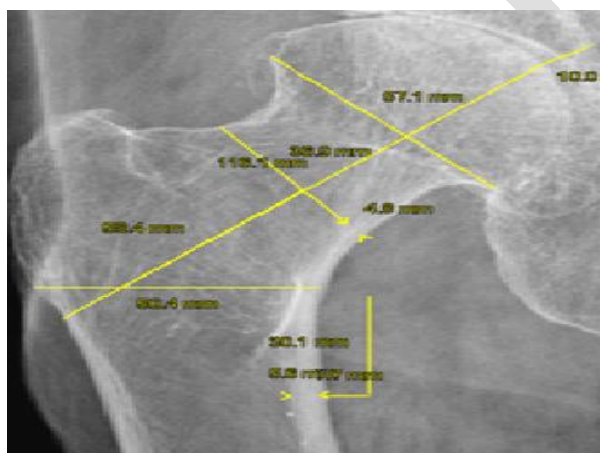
Hip geometrical measurements on a digital radiograph of osteoporosis Post Menopausal Indian woman aged: 80, the measured Total hip BMD by the DXA in the same individual was: 0.506 g/ Cm 2 .
